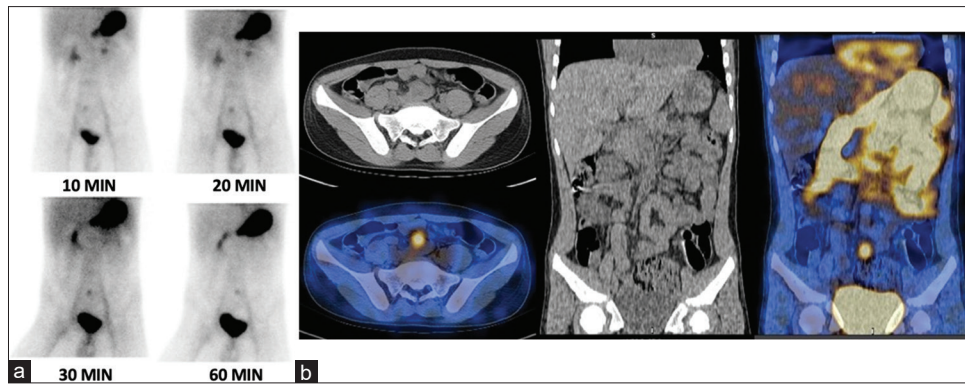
(a and b) A Tc-99m pertechnetate scan was performed again with similar acquisition protocol, and this time along with the stomach, a small focal area of increased radiotracer accumulation was noted in the hypogastric region in the midline (thin arrow), which corresponded to the region of distal ileum in the correlative transaxial and coronal SPECT-CT (notched arrow). This discrepancy in the findings of the radionuclide study is worth pondering. SPECT/CT: Single-photon emission computed tomography/computed tomography
